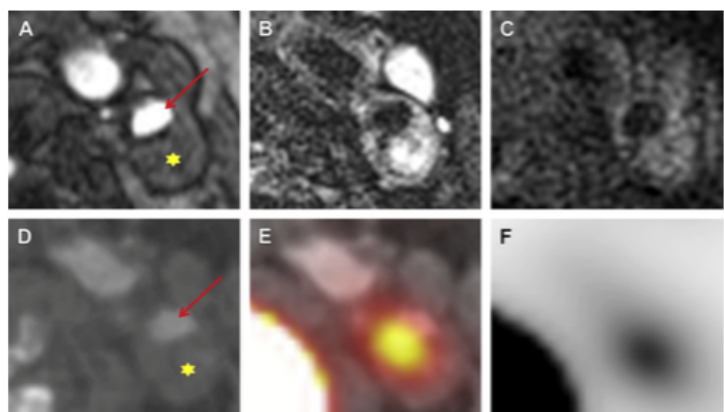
Symptomatic carotid plaque on MRA (3T) and ^{18}F PET-CT. The red arrow denotes the lumen of the internal carotid artery, and the yellow star denotes culprit haemorrhagic plaque with intense ^{18}F -Fluoride uptake. (A) Axial time-of-flight MRA. (B) T2-weighted image. (C) T1-weighted image. (D) CTA. (E) Fused PET-CT. (F) ^{18}F -Fluoride PET.
